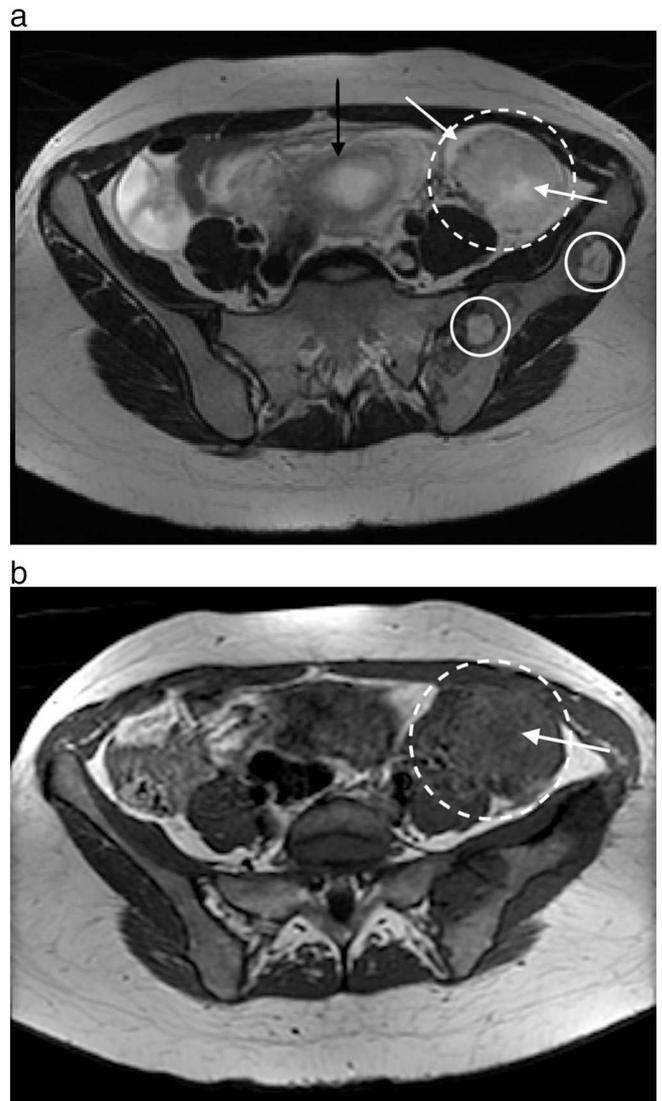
a. Pelvic MRI with axial T2-weighted image demonstrates T2 hyperintense left pelvic mass (dashed circle) with internal and peripheral cystic components (white arrows). Lobulated hyperintense lesions incidentally noted in the left iliac bone are consistent with enchondromas (solid circles). The gravid uterus is partially seen (black arrow). b. Pelvic MRI with axial T1-weighted image demonstrates corresponding T1 isointensity of the left pelvic mass (dashed circle) with internal hypointensity consistent with cystic component seen on T2-weighted images (white arrow). No macroscopic fat is identified within the mass.
